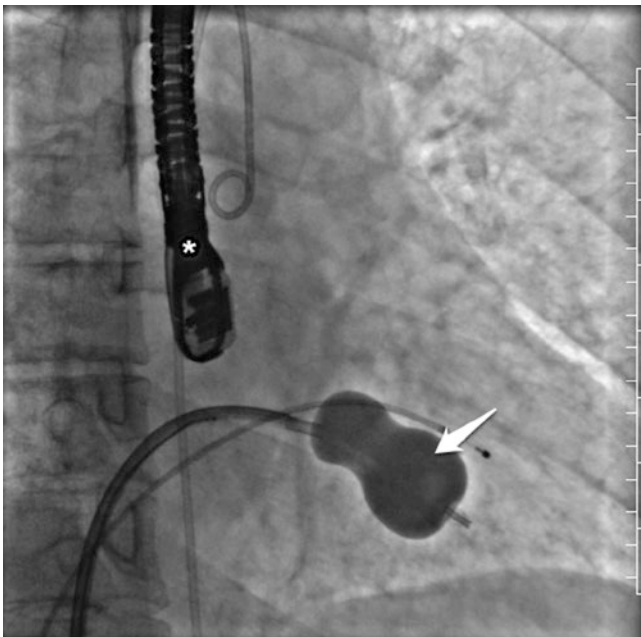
This is a frame from fluoroscopy during valvuloplasty. The balloon is currently inflated (arrow) and the “neck” of the balloon where the mitral valve is. This particular procedure is done under guidance of a transesophageal echocardiogram (*) and hemodynamic monitoring
